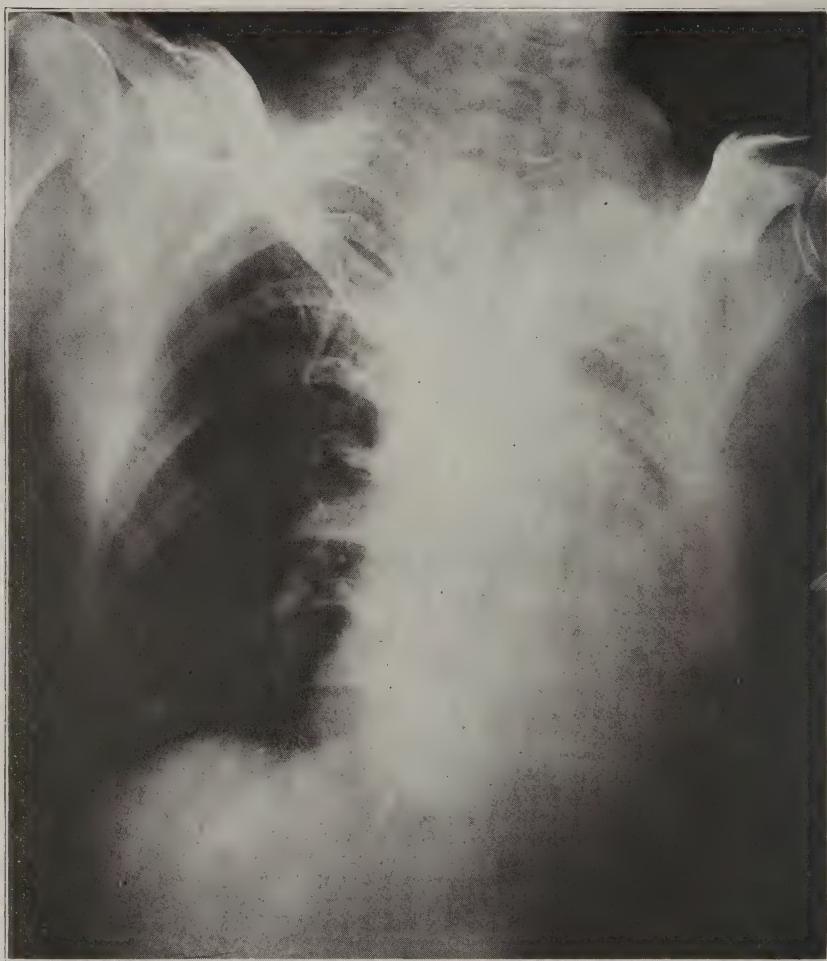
Roentgenogram (No. 18161, University of California Hospital, Roentgen-Ray Department, March 6, 1920) taken with the patient in the prone position (anterior-posterior view).
